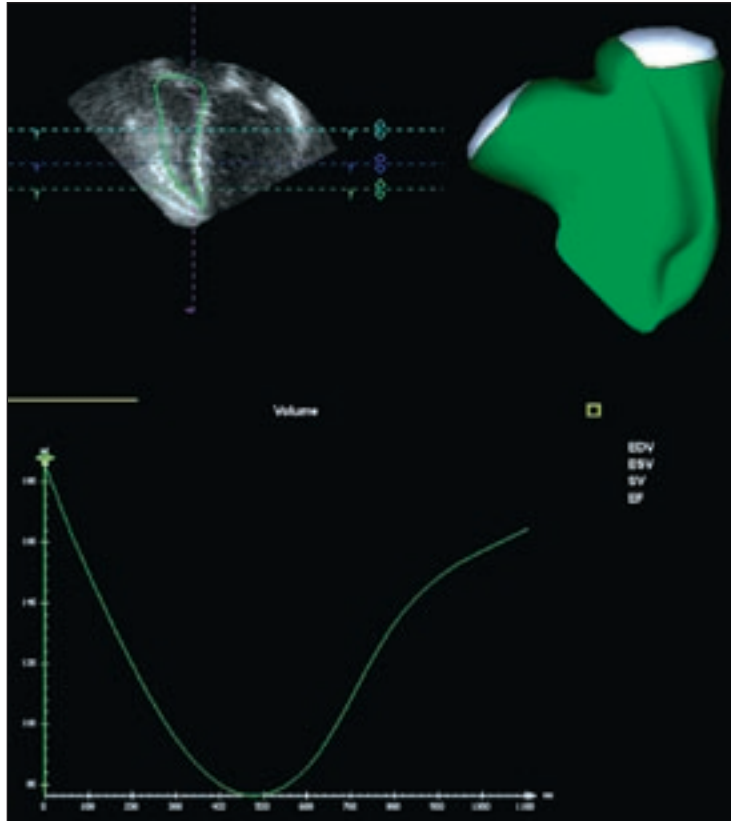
3D Echocardiography for RV Volumes and Systolic Function. Top left, A single-slice 2D echo cut through the right ventricle (RV) with a representative endocardial trace generated by automatic contour tracking software once multiple key right heart landmarks are identified and marked. Top right, The 3D representation of the RV made by stacking multiple 2D echo slices similar to the figure at left (individual slices are tracked, not predicted by any geometric assumptions). Below these images is the time-volume curve for the right ventricle.
